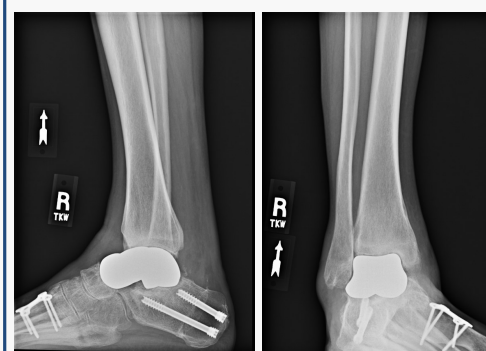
(Above) 20 months post-operative radiographs
